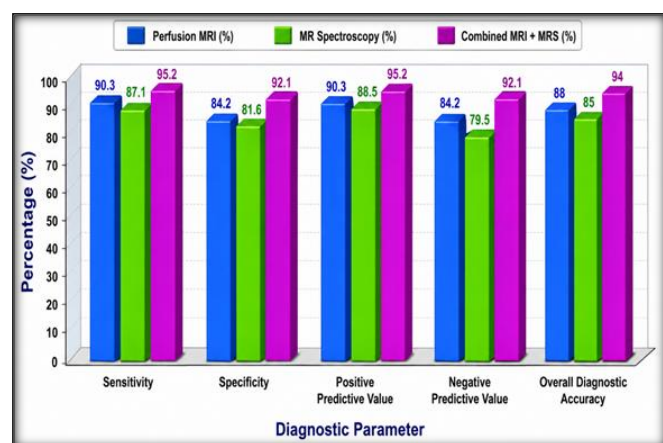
Diagnostic Performance of Perfusion MRI, MRS, and Combined MRI
